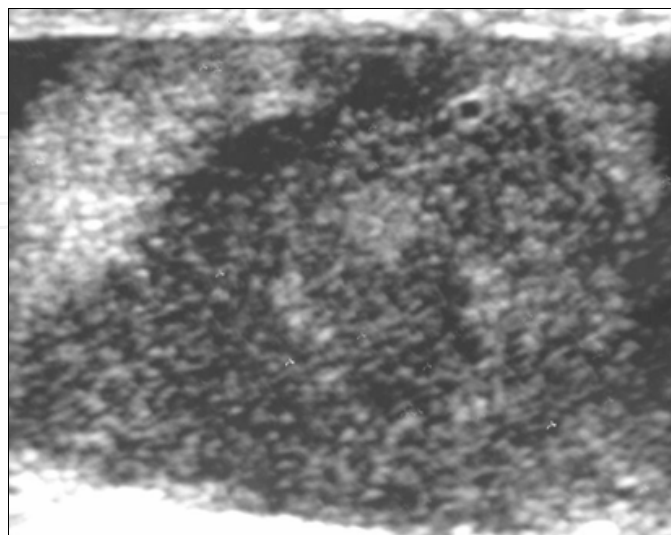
Lymphoma. Lymphoma in a 61 year-old man. Longitudinal sonography shows an irregular hypoechoic lesion occupied nearly the whole testis
